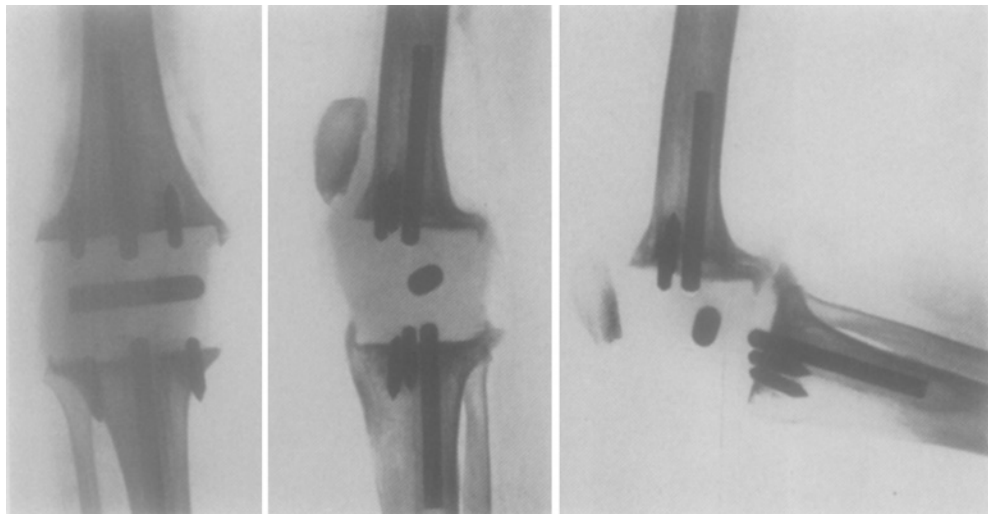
Case 4: roentgenograms of right knee 4 years 4 months after arthroplasty.
